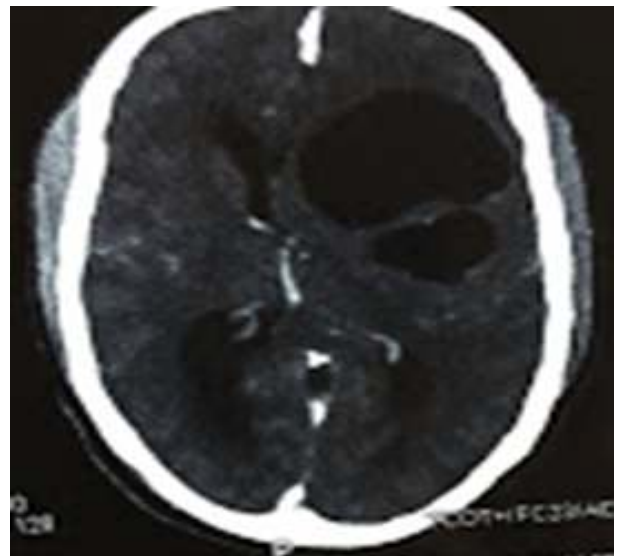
Brain CT showing a left frontal bi-lobed cystic lesion with significant midline shift.
